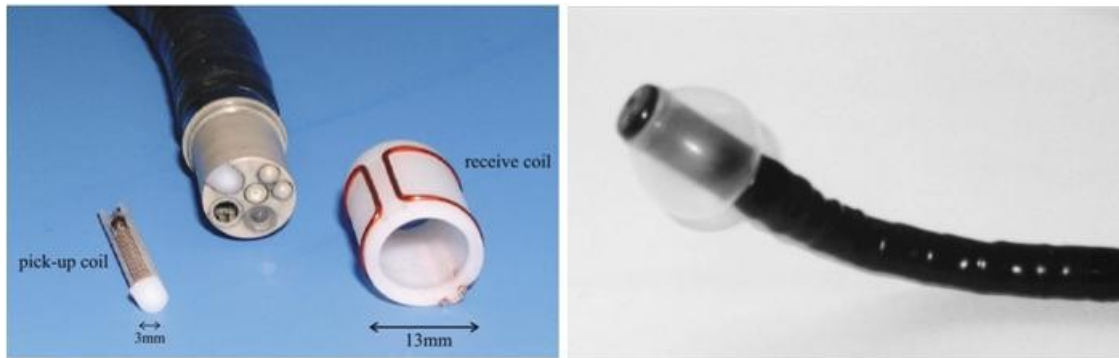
MRI compatible endoscopes manufactured by Endsocan Ltd (l, with removable tip receiver coil) and Olympus (r, with inflatable latex balloon for positioning stability) [Gilderdale, 2003; Ichikawa, 2001].
